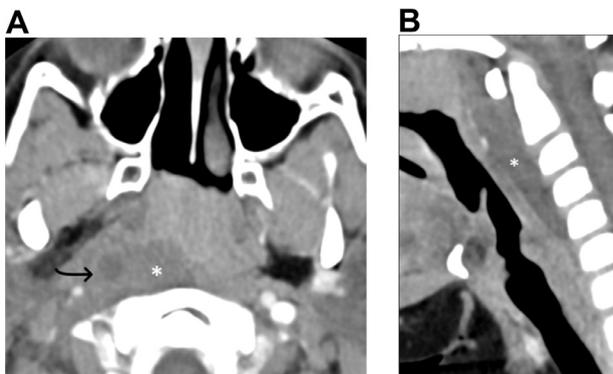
Retropharyngeal abscess: 7-year-old female presenting with worsening neck pain, difficulty swallowing and swelling. Contrast enhanced axial CT neck (A) with sagittal reconstruction (B) reveals an enhancing retropharyngeal hypodense fluid collection causing distention of the retropharyngeal space with convex anterior borders (*) consistent with a retropharyngeal abscess. Suppurative retropharyngeal lymph node is also seen (A arrow) that likely ruptured into the retropharyngeal space causing abscess formation.
